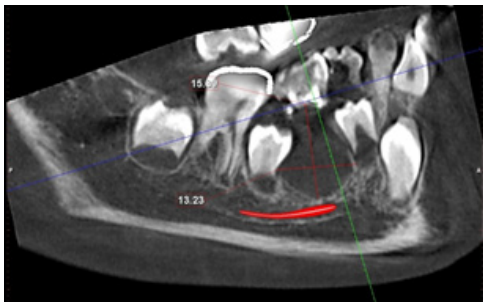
CBCT showing radiolucent lesion of size approximately 13.23mm antero-posteriorly, 15.8mm superior-inferiorly and 12.8mm bucco-lingually.
